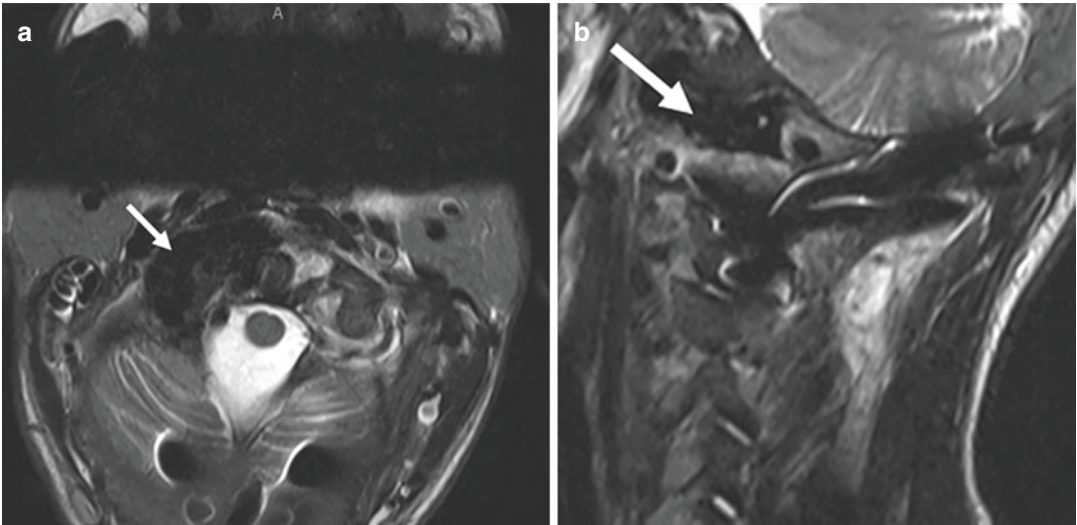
Brown tumor. Axial (a) and sagittal (b) T2-weighted MRIs of the craniocervical junction demonstrating a homogeneously hypointense brown tumor (arrow) in the C1 lateral mass
